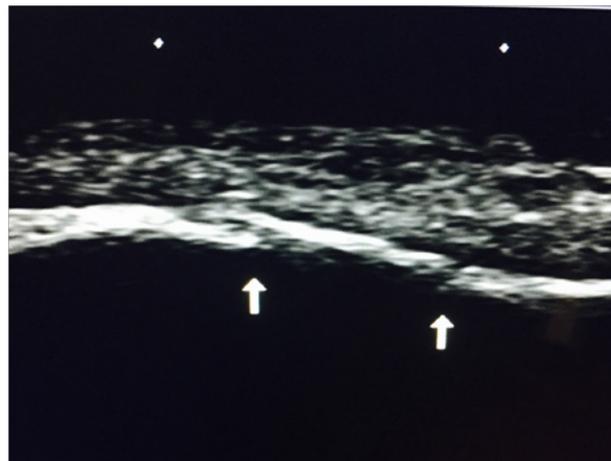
The same patient was gone through a detailed ultrasound showing multiple fractures with overlying small hematomas.
